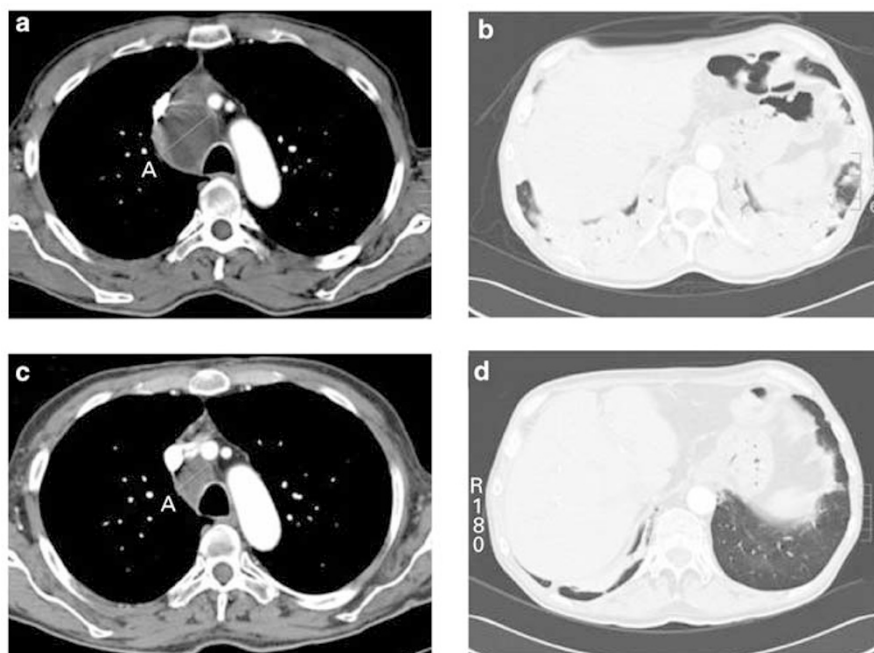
CT scan of patient at day +120 (a, b) and +190 after allogeneic transplantation (c, d).
